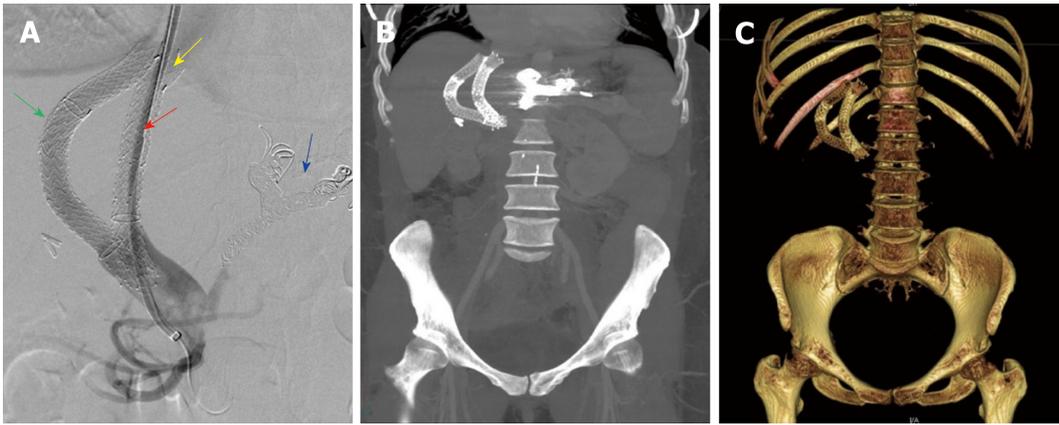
Imaging examinations of patient 1. A: Digital subtracted portal angiography showing successful placement of the parallel stent (red arrow) with caval extension (yellow arrow). Embolization coils can be seen the coronary vein branches (blue arrow). Primary stent (green arrow) is seen alongside the second transjugular intrahepatic portosystemic shunt stent. B: Maximum intensity projection with 30-mm slab of post procedural computed tomography (CT) abdomen showing primary and parallel stents in tandem. C: 3D reconstruction of a post procedural CT abdomen showing primary and parallel stents in tandem.
